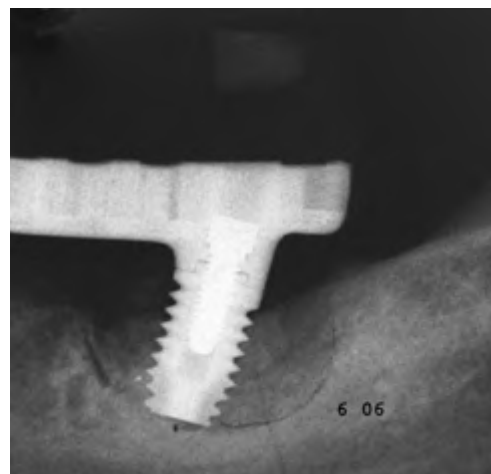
This radiograph was taken 3 years post loading. The patient complained of chronic discomfort in the left posterior mandibular area. The radiograph demonstrated a significant radiolucency around the left distal implant (outlined in pencil). The framework was removed, and the implant was extremely mobile. This implant probably was placed too far distal and with mandibular movements, significant forces were placed onto the implant and resulted in severe bone loss and loss of the implant. The prosthesis was sectioned distal to the next anterior implant in the left posterior quadrant and polished, and the patient was discharged without further incident or implant loss over the next 3 years.
